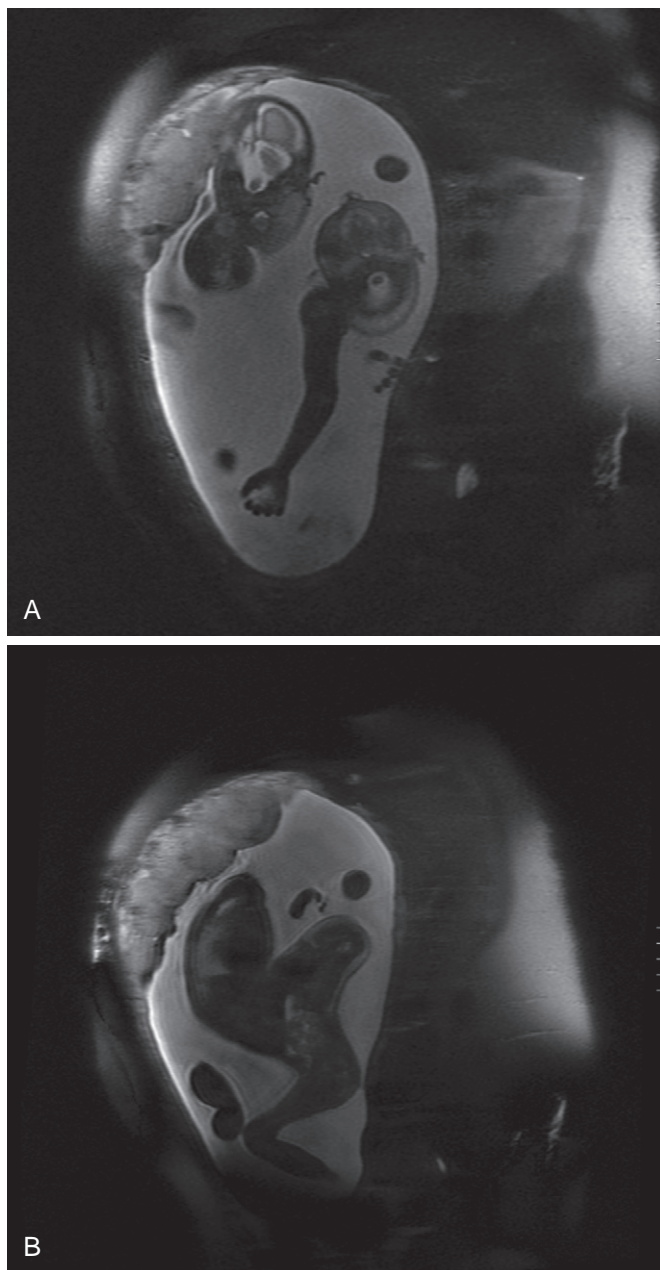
A, Prenatal magnetic resonance imaging of conjoined twins. B, Scan of twins showing abdominal conjunction.
